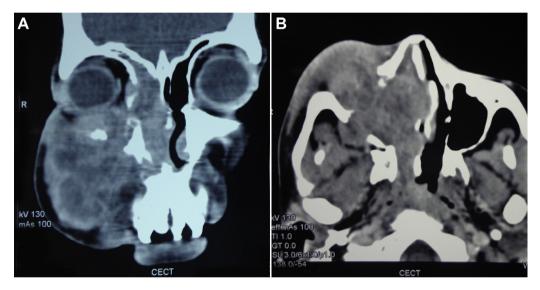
Contrast enhanced computed tomographic scan of paranasal sinuses showing a large heterogeneously enhancing mass involving the right maxillary sinus causing destruction of the superior, anterior, posterior and medial wall of the maxilla with extension into right orbit involving the periorbital tissue (A: coronal section; B: axial section).
